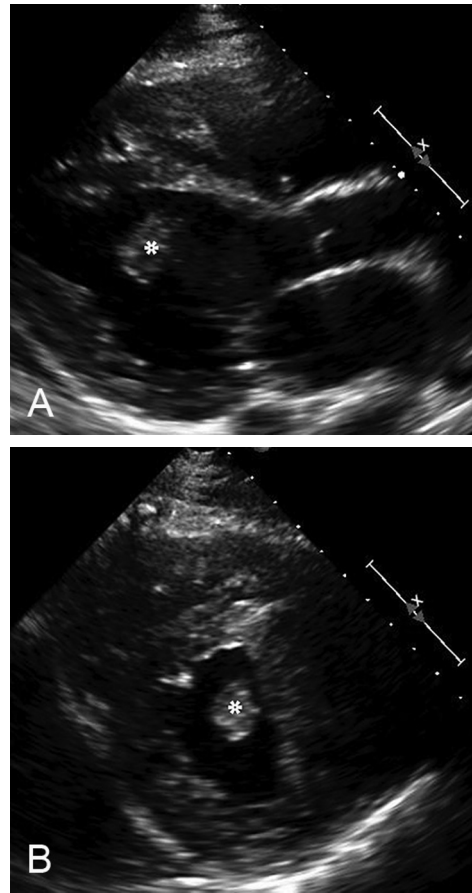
46-year-old female with spindle-cell sarcoma of the heart. Parasternal long-axis (A) and short-axis (B) views showed an echogenic mass in the left ventricular lumen (asterisk) and thickening of the left ventricular wall.
